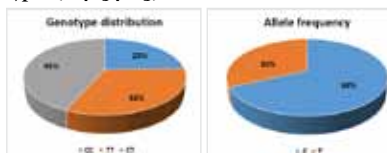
Genotype distribution and allele frequencies. CC/CT—normal risk, TT—high-risk for aggressive PC
